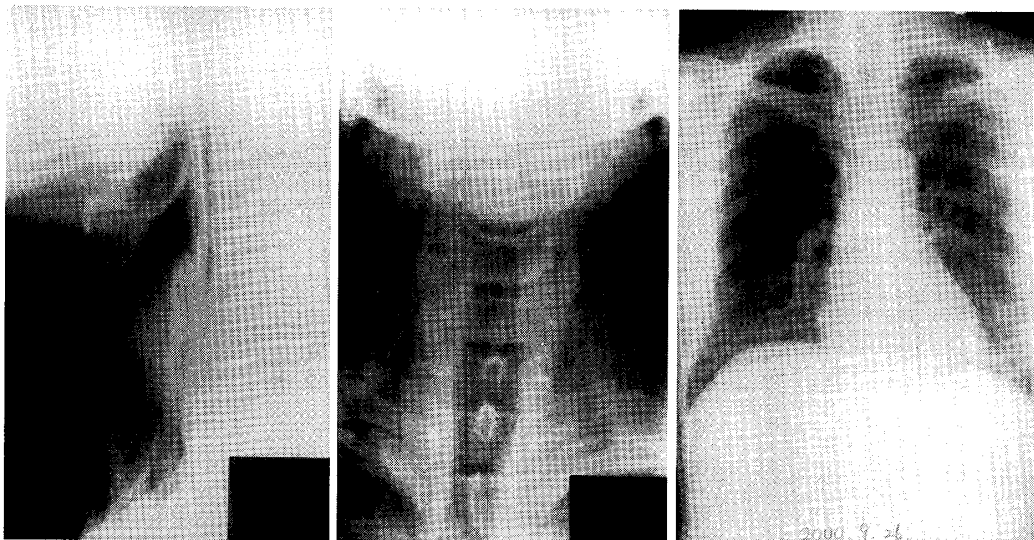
Plain X-ray film of the neck and chest
